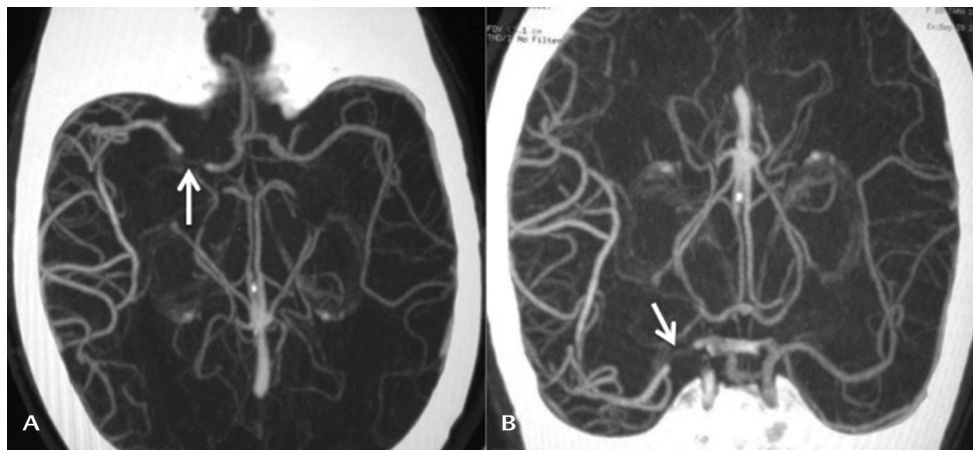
Axial (A) and coronal (B) maximum intensity projection formats of computed tomography (CT) angiography demonstrating very good collateral score, depicted by complete opacification of middle cerebral artery (MCA) territory distal to the thrombus (arrow).
